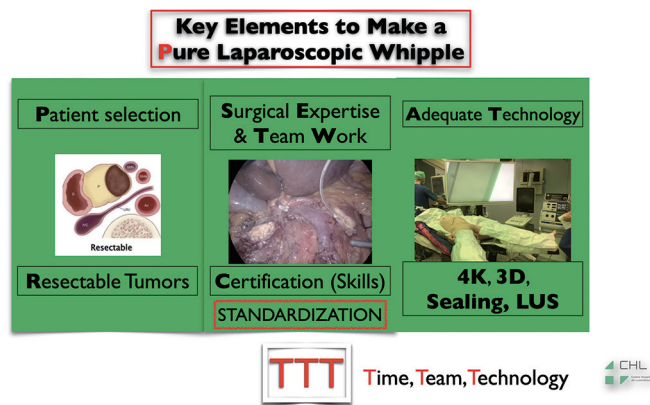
Key elements for achieving the MILPD. MILPD, minimally invasive laparoscopic pancreaticoduodenectomy; 4K, 4K resolution for the camera; 3D, three-dimensional visualization; LUS, laparoscopic ultrasound.
